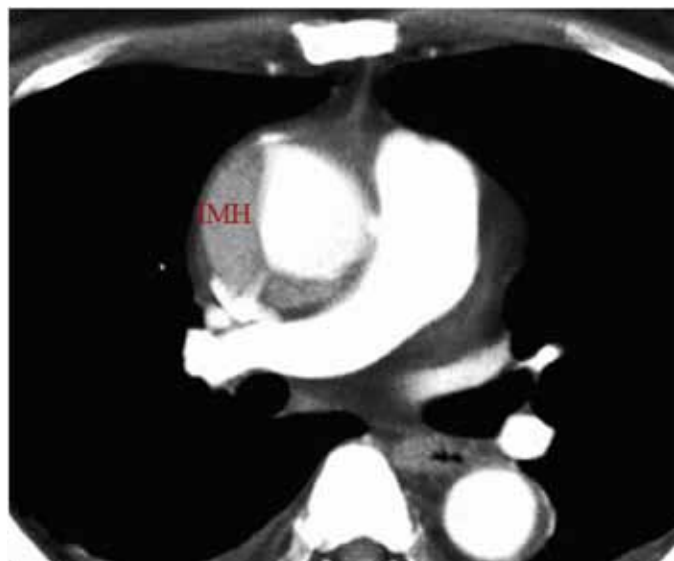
Computed tomography scan showing an intramural hematoma in the ascending aorta.
